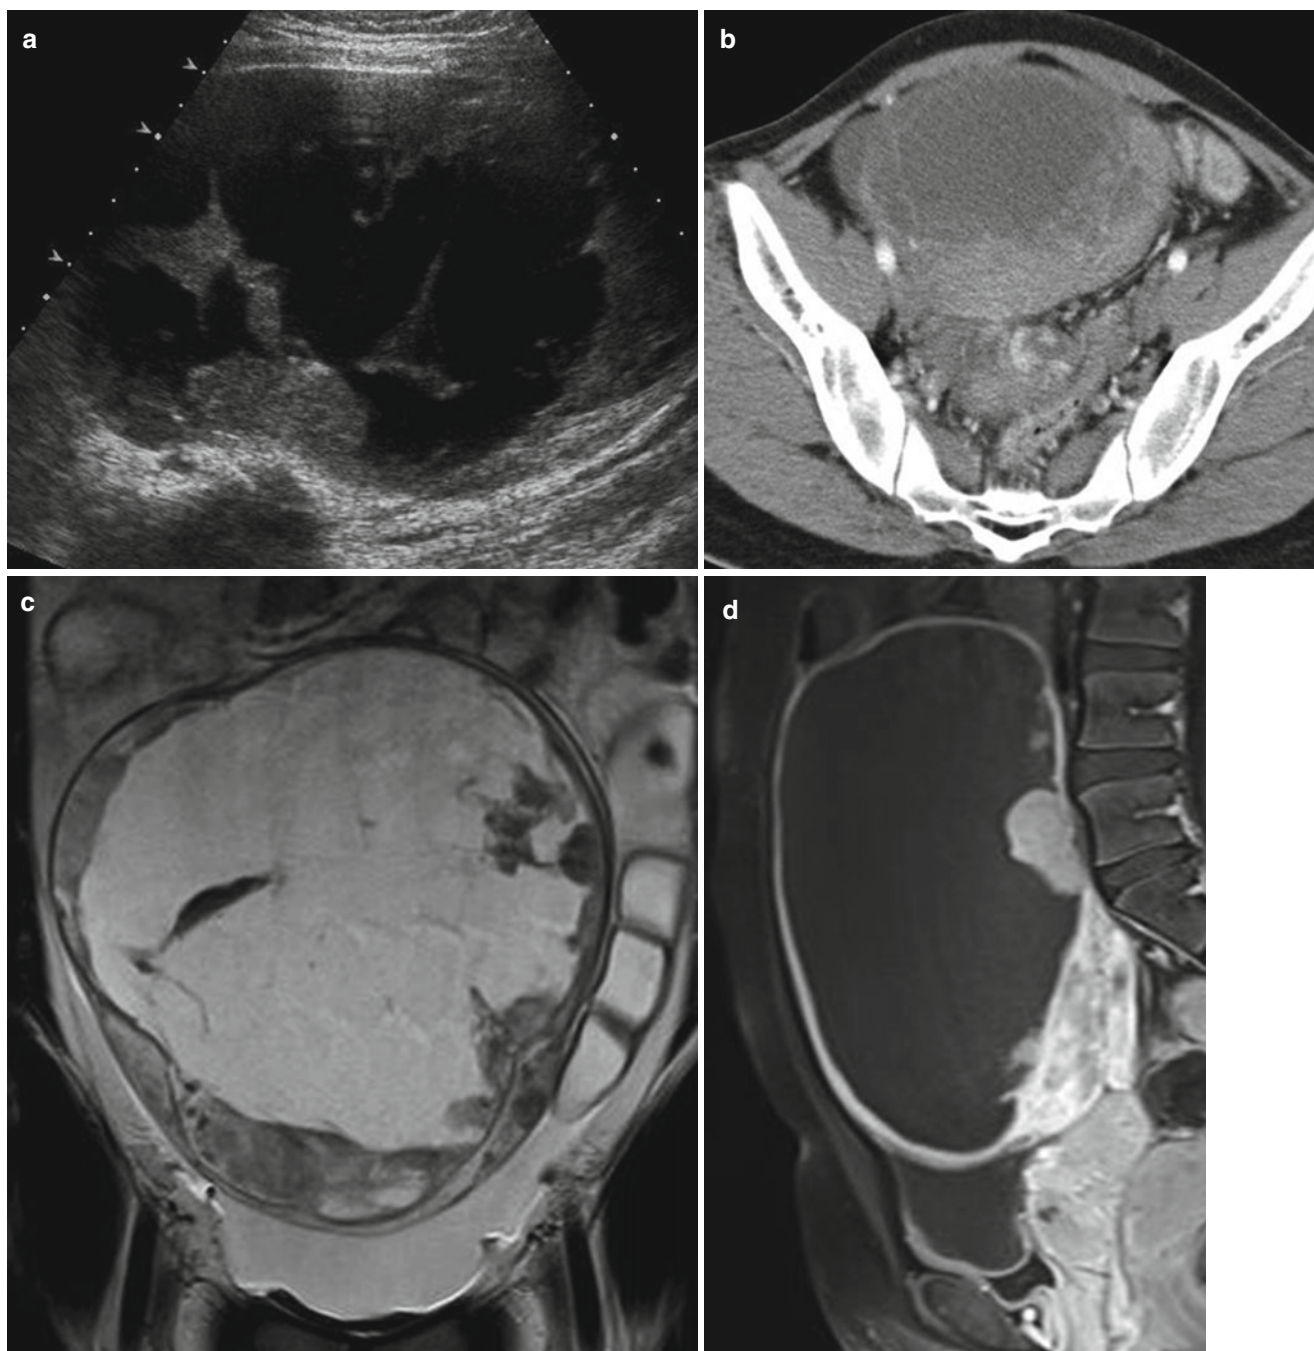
Mixed germ cell tumor composed of dysgerminoma and endodermal sinus tumor in a 16-year-old girl. (a) Axial US scan of pelvis shows large cystic mass with septa and some solid portions. (b) Contrast-enhanced axial CT scan shows a large mass with enhancing septa and solid portions. (c) T2-weighted coronal MR image shows a
